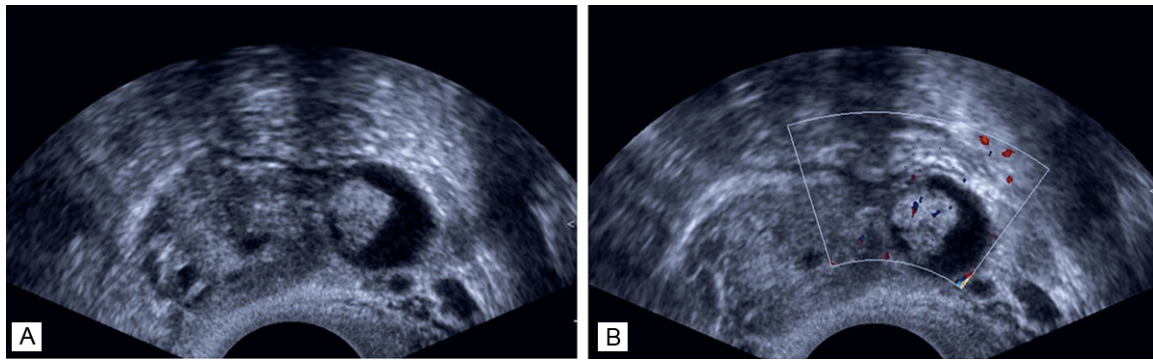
Transvaginal ultrasound images of case 3. A. The parovarian unilocular hypoechoic cyst was close to but separate from the ipsilateral ovary. Note the presence of the papilla growing from the cyst wall. B. The vascular signals within the papilla were shown.
